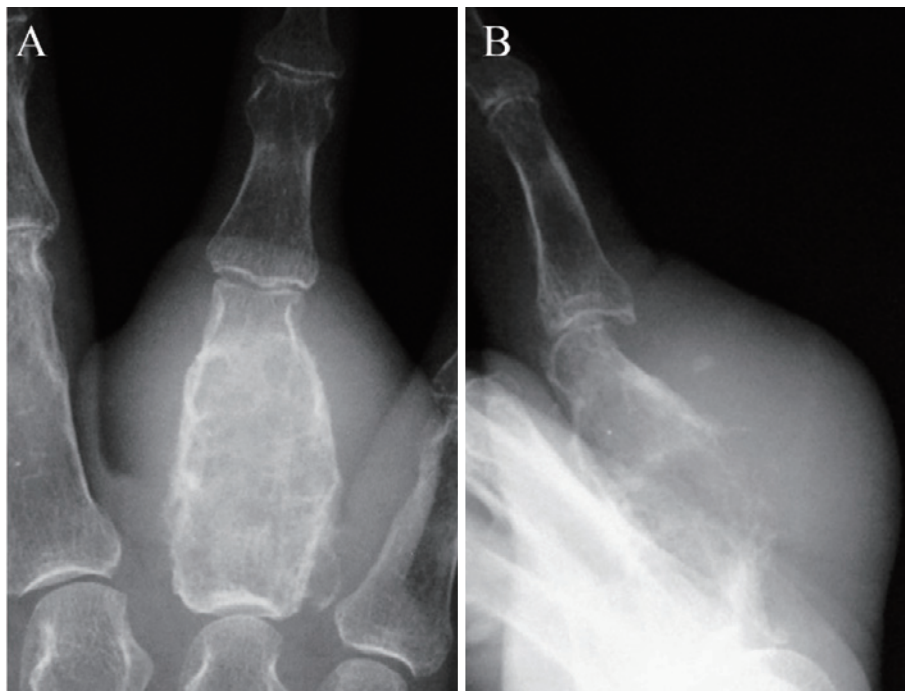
Radiographs of the patient's right ring finger taken eight years after his first visit, showing a radiotransparent space-occupying lesion with periosteal reaction and a concomitant dorsal cortical break of the proximal phalange of the ring finger.
